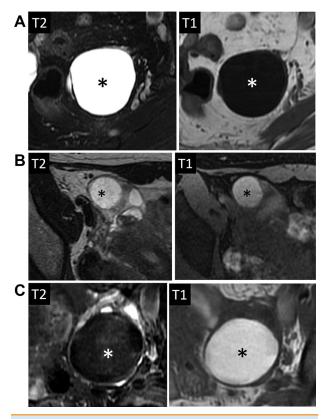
Fluid descriptors. (A) Simple: fluid content that follows CSF or urine on all sequences; hyperintense on T2weighted imaging (T2WI) (black asterisk) and hypointense on T1-weighted imaging (T1WI) (white asterisk). (B) Hemorrhagic fluid: variable depending on age; late subacute hemorrhage is hyperintense on T2WI (black asterisk) and hyperintense on T1WI (white asterisk). (C) Endometriotic fluid: hypointense on T2WI (white asterisk) and hyperintense on T1WI (black asterisk). (D) Proteinaceous: variable in signal on T2WI (white and black asterisks; left image) and variably hypointense on T1WI (white and black asterisks right image). (E) Fat or lipid containing: hyperintense on T2WI and hyperintense on T1WI (black asterisk), and loses signal on fat-saturated images (white asterisk).
